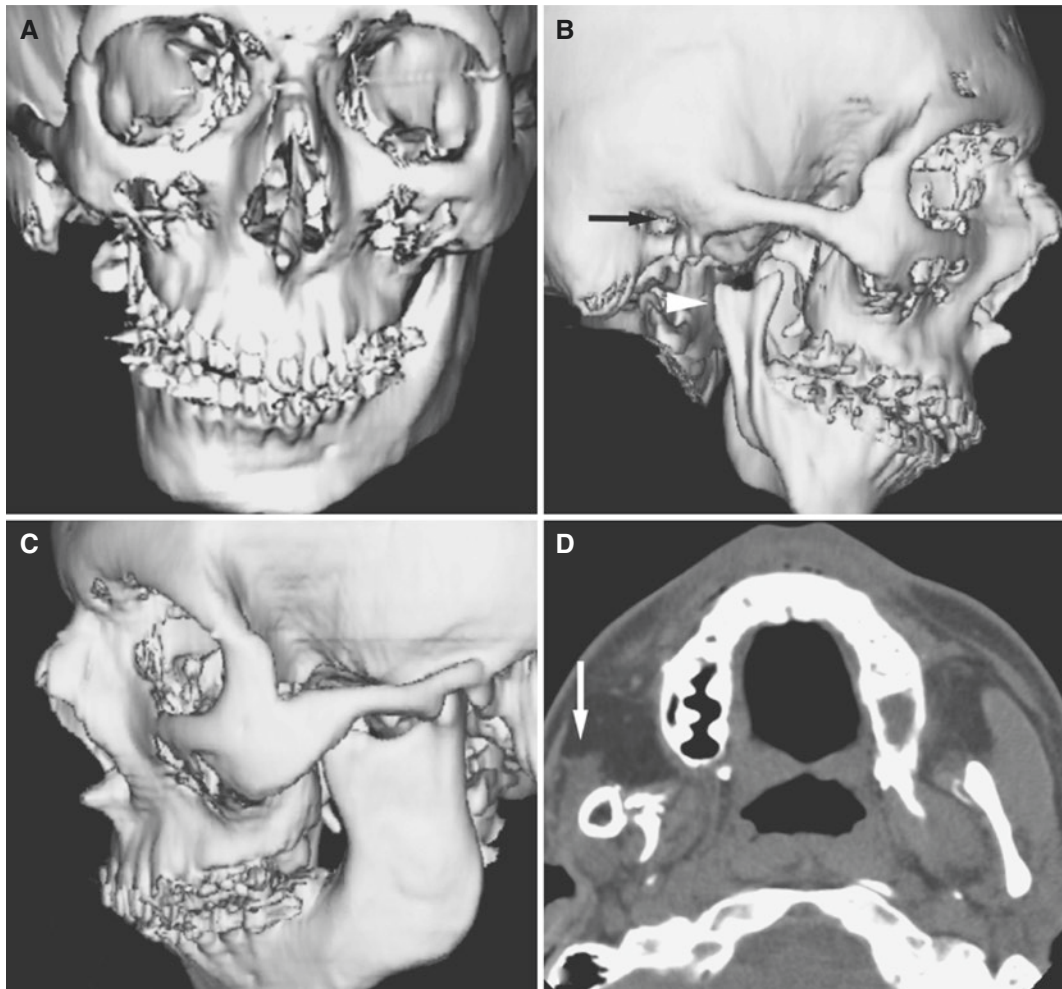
Hemifacial microsomia; 17-year-old male; pre- and postoperatively. (A) 3D CT image, en face view, shows facial asymmetry due to right-sided mandibular hypoplasia. (B) 3D CT image, lateral view, shows right-sided zygomatic arch without glenoid fossa (*arrow*) and hypoplastic mandible without mandibular condyle (*arrowhead*). Note orthodontic braces on the teeth. (C) 3D CT image, lateral view, shows normal left side for comparison. (D) Axial CT image, soft tissue, shows severe atrophy of the right masseter muscle (*arrow*) compared to normal left side. (E) Coronal CT image, soft tissue, shows severe atrophy of the masseter muscle (*arrow*) and temporalis muscle (*arrowhead*)
